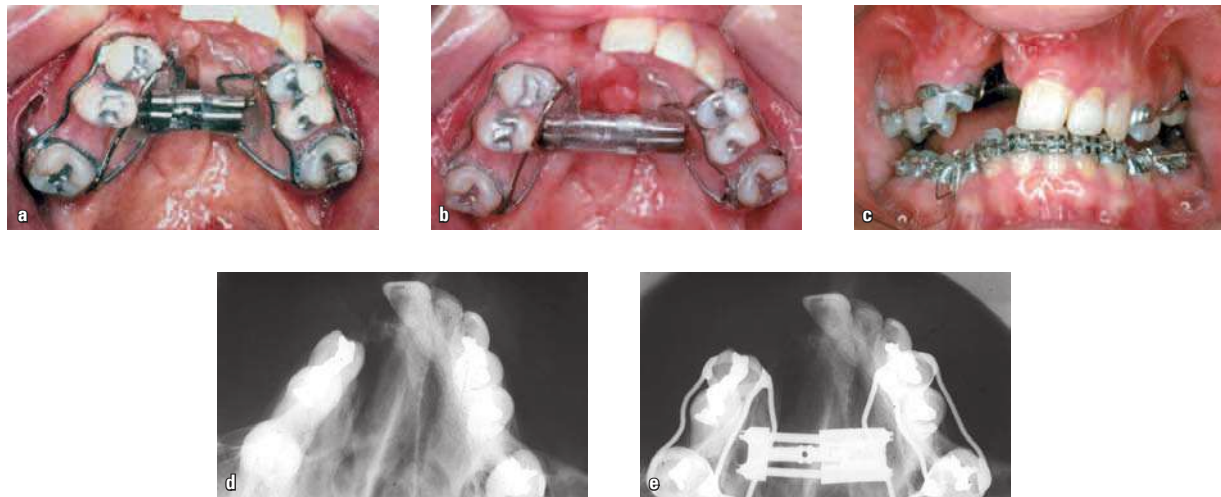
Upper arch with expander in place, before activation (a), after activation (b), frontal occlusion (c), occlusal radiograph of maxilla before (d), and after expansion (e).
